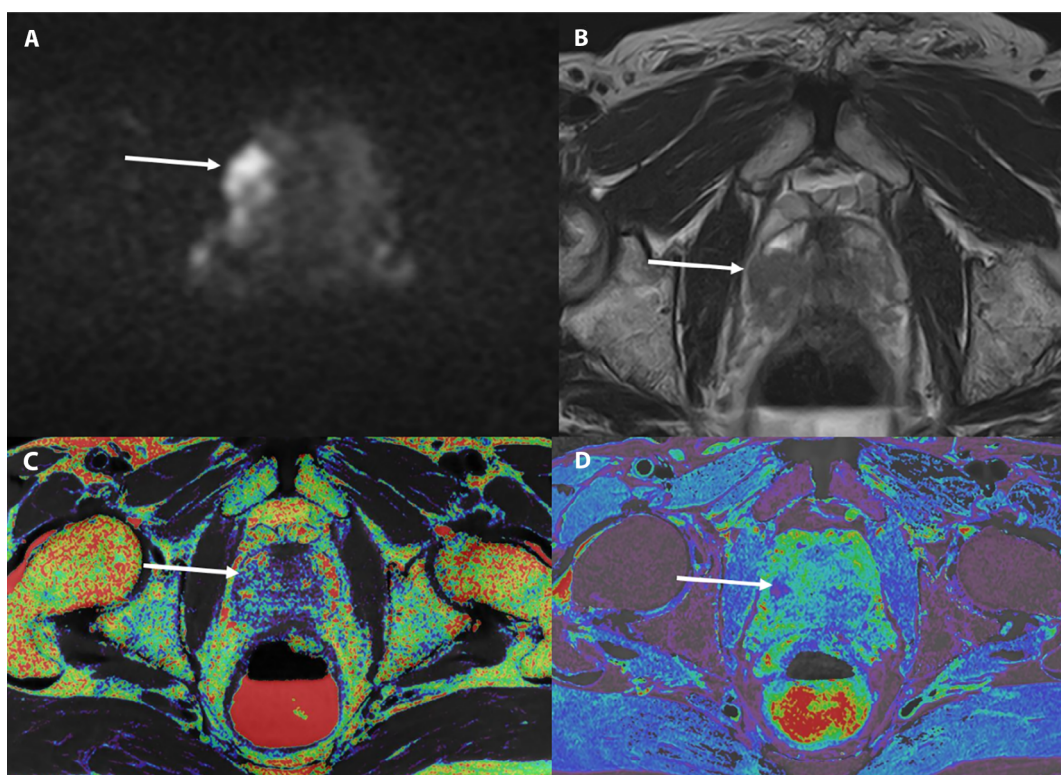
Example of a patient with a lesion in the peripheral zone. A diffusion restriction (A, DWI, B 1600) and a hypointense T2 signal is seen (B), corresponding to a PIRADS vs 5. This lesion is not clearly visualized in the T1 (C) but is clearly seen T2 (D) maps. However, ROIs drawn in the lesion on the DWI and copied and pasted in the same position on the maps showed a different T1 of the lesion (1450 ms) vs the normal peripheral zone contralateral (2000 ms) and a different T2 of the lesion (60 ms) vs the normal peripheral zone contralateral (255 ms).
